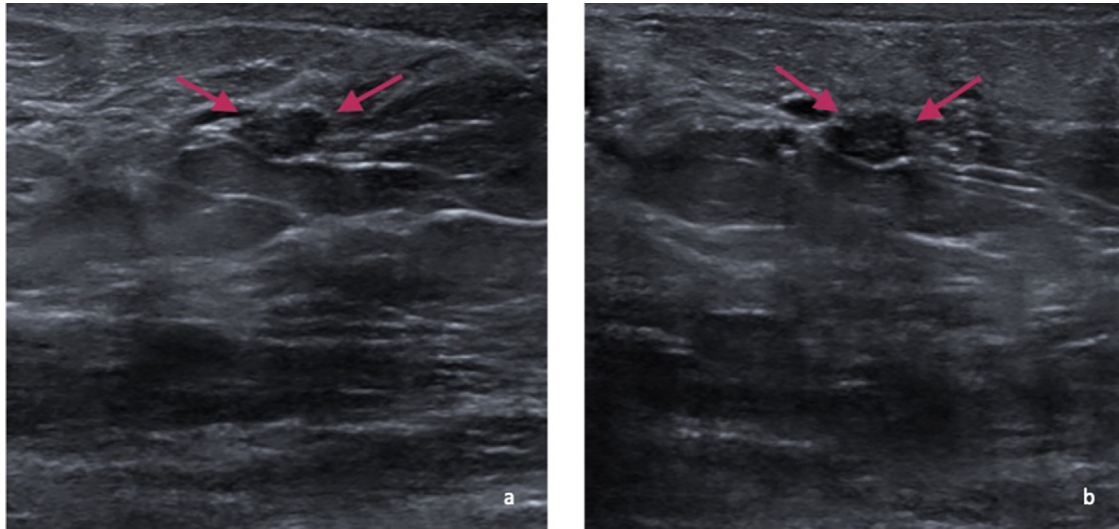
Targeted ultrasound of the right retroareolar breast ([A] transverse, [B] longitudinal) showed a 6 mm x 3 mm x 6 mm solid mass (pink arrow) at 11’0 clock, 1 cm from the nipple.
